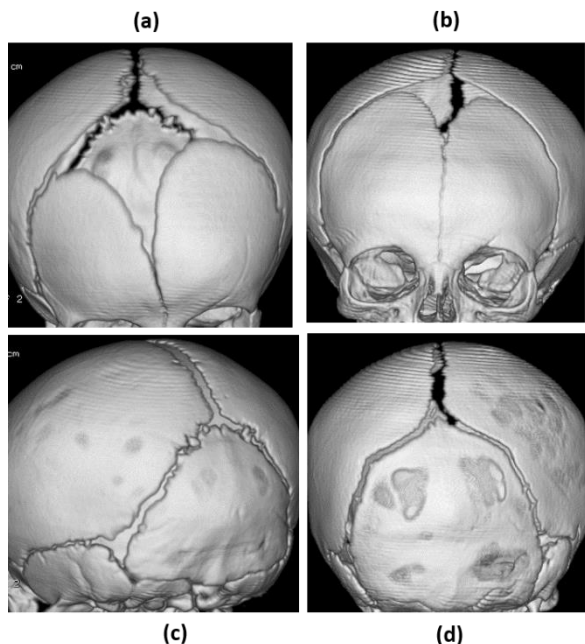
The diagnostic image quality of three dimensional skull CT views of Frontal (a) and postero-lateral (c) views of standard dose (100 kVp, 120 mAs) protocol of 2 months' baby are comparable to frontal (b) and posterior (d) views of reduced dose (80 kVp, 96 mAs) protocol of 3 months' baby .
